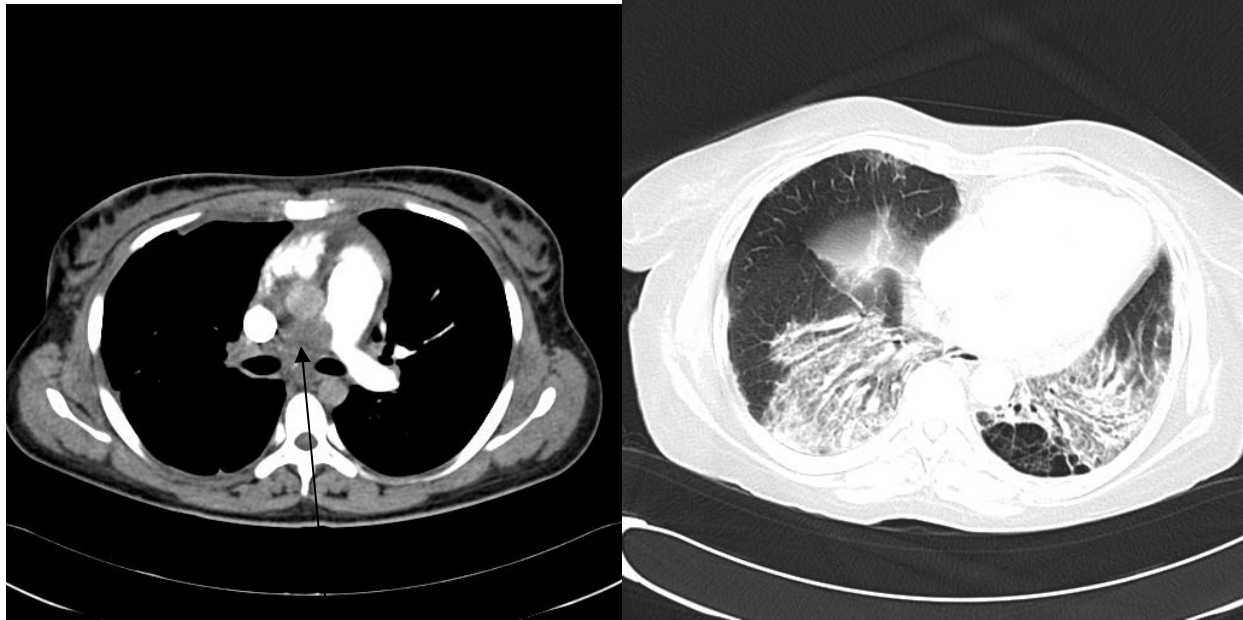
(a) Axial CT- RPA thrombus(vessel cut-off sign)
